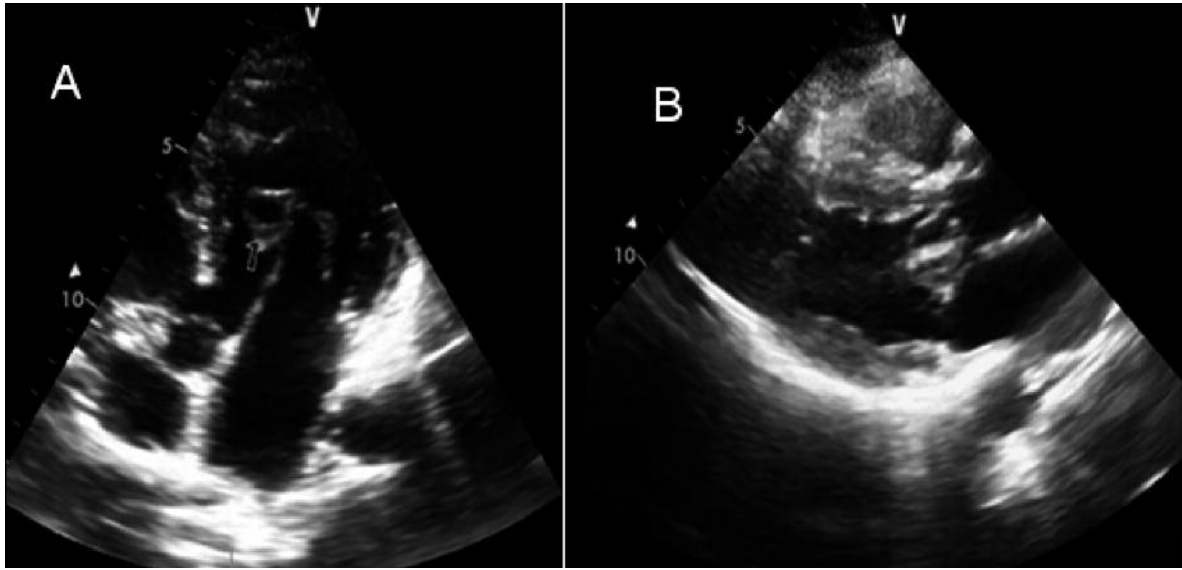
A, Echocardiographic images of 55 years old female patient from apical four chamber view. B, Parasternal long axis image, recorded during systole.
